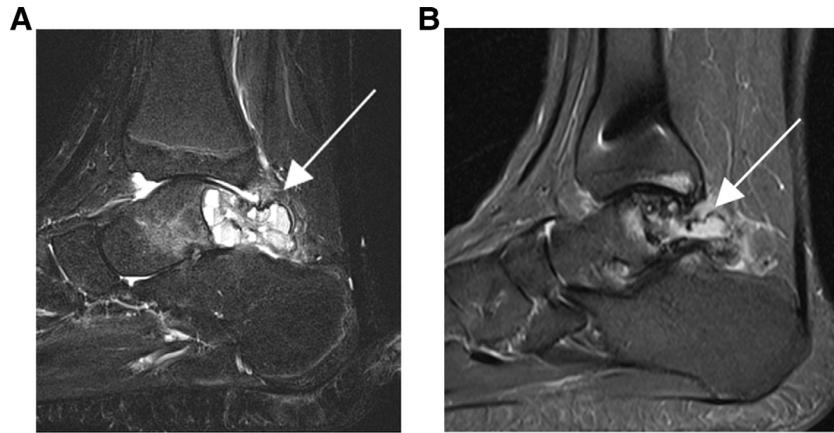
A 13-year-old girl with an aneurysmal bone cyst of the posterior talus placing the patient at risk for pathologic fracture. The lesion was incidentally noted during workup for a fracture of the distal tibia. Initial sagittal T2-weighted MR image (A) demonstrates a predominantly T2-hyperintense, lobular, multiseptated cystic lesion (white arrow) of the posterior talus with fluid levels. There is some edema in the surrounding soft tissues and a small ankle effusion. Sagittal proton density MR image (B) following multiple treatments with doxycycline sclerotherapy and cryoablation shows contraction of the lesion with areas of dense sclerosis and mild persistent fluid-filled cystic component (white arrow). Note the susceptibility artifact from hardware in the distal tibia.
